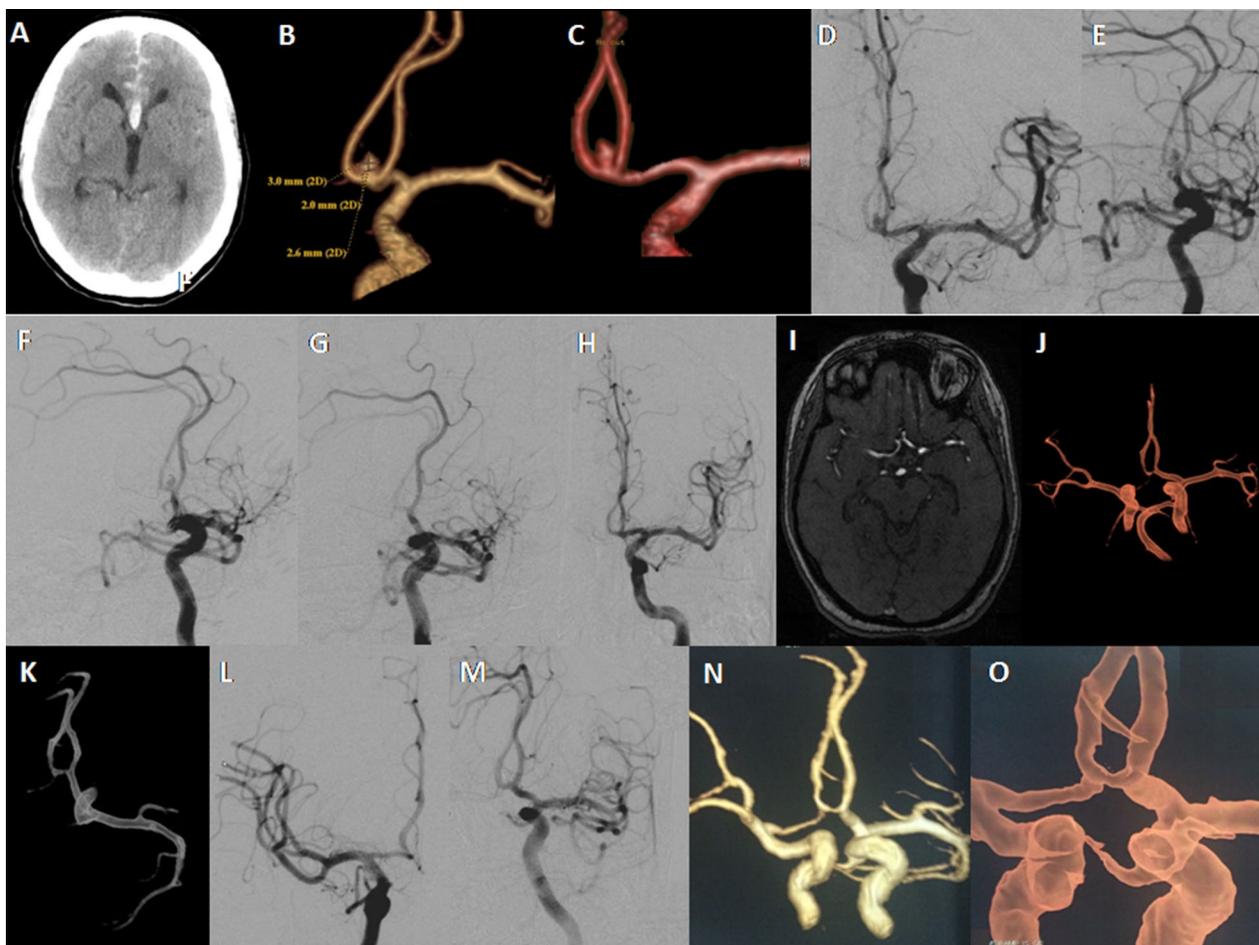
GA case 52-year-old lady presented to our hospital by SAH from ruptured AcomA aneurysm H&H=3. A Non-enhanced axial CT brain showed diffuse SAH with main cast at the anterior interhemispheric fissure, B, C preoperative CT angiogram volume rendering 3D reformat showed a small narrow neck AcomA aneurysm directed anterosuperiorly with the following dimensions (3.0 × 2.0 × 2.6 mm), D, E preoperative A-P view and working view angle DSA showing the AcomA aneurysm before coiling, F preoperative DSA working angle view showing the microcatheter inside AcomA aneurysm before coiling, G, H post-coiling (under GA) working angle view and A-P view DSA showing complete aneurysm obliteration (CO), I axial source image MRA 6-month FU showing stable aneurysm obliteration, J, K postprocedural 6-month FU MRA 3D volume rendering transparent format that showed stable complete aneurysm obliteration (CO), L, M 1-year FU DSA Rt. ICA A-p view and left ICA working angle view that showed stable complete obliteration (CO), N, O 3-year postprocedural FU MRA 3D volume rendering transparent format that showed stable complete aneurysm obliteration (CO).
